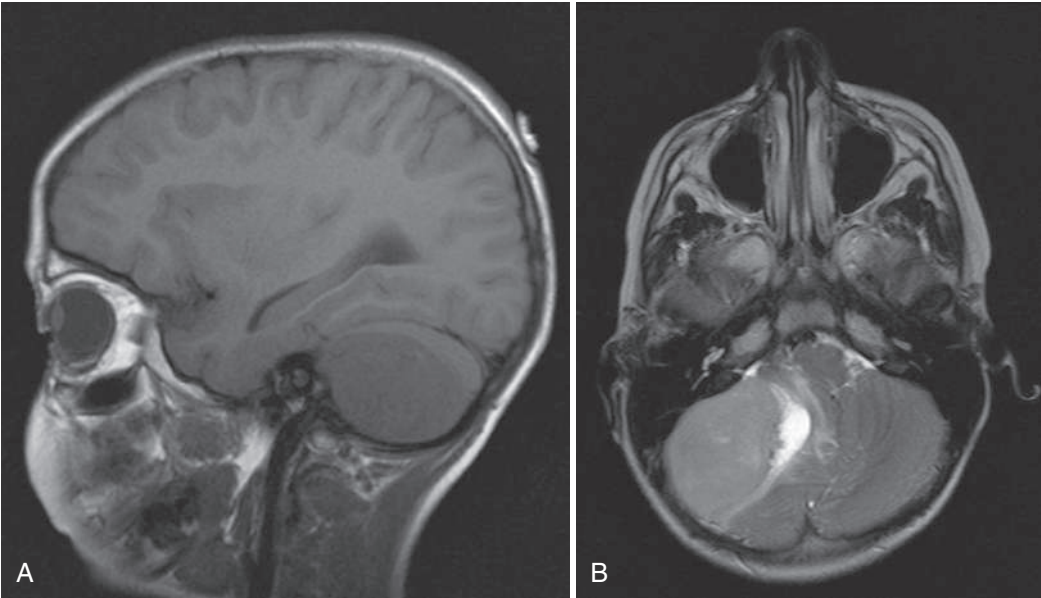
A, Sagittal T1-weighted MR image shows hypointense mass involving the cerebellar hemisphere in a 6-yr-old child with desmoplastic variant of medulloblastoma. B, Axial T2-weighted image of the same child shows hyperintense mass involving the cerebellar hemisphere.
